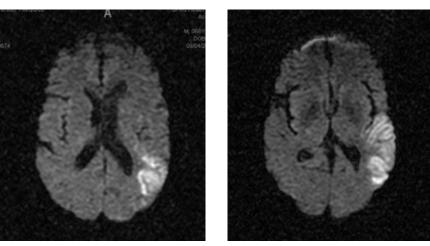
Diffusion Weighted MRI obtained after the procedure was completed. Acute stroke is present in the posterior inferior middle cerebral artery.
